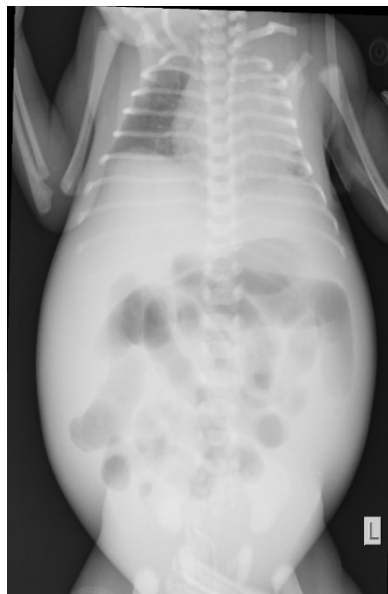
Chest and abdominal radiograph showing cardiomegaly, reduction of the left lung field with ipsilateral shift of the mediastinum and some rib crowding suggesting some collapse and fracture of the mid-portion of the left clavicle. There is ascites, enlarged liver and gaseous distension of the small intestines
